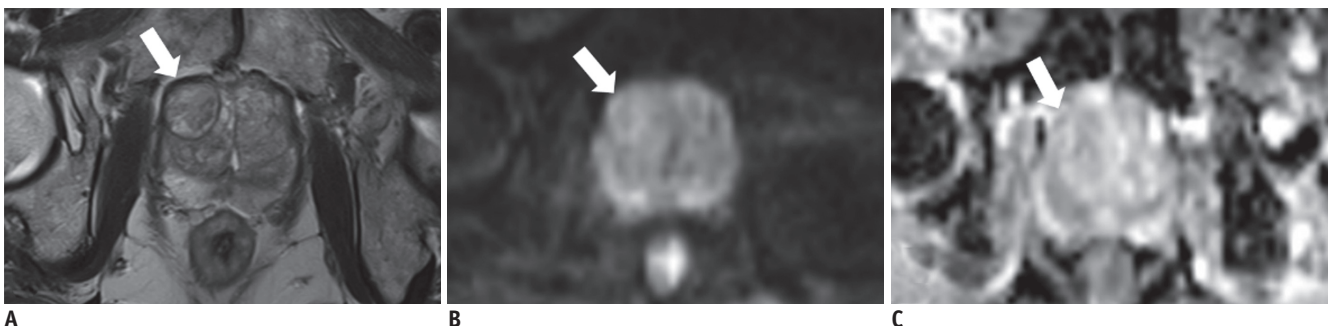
MRI report of this case was generated in structured format of report C-a.
